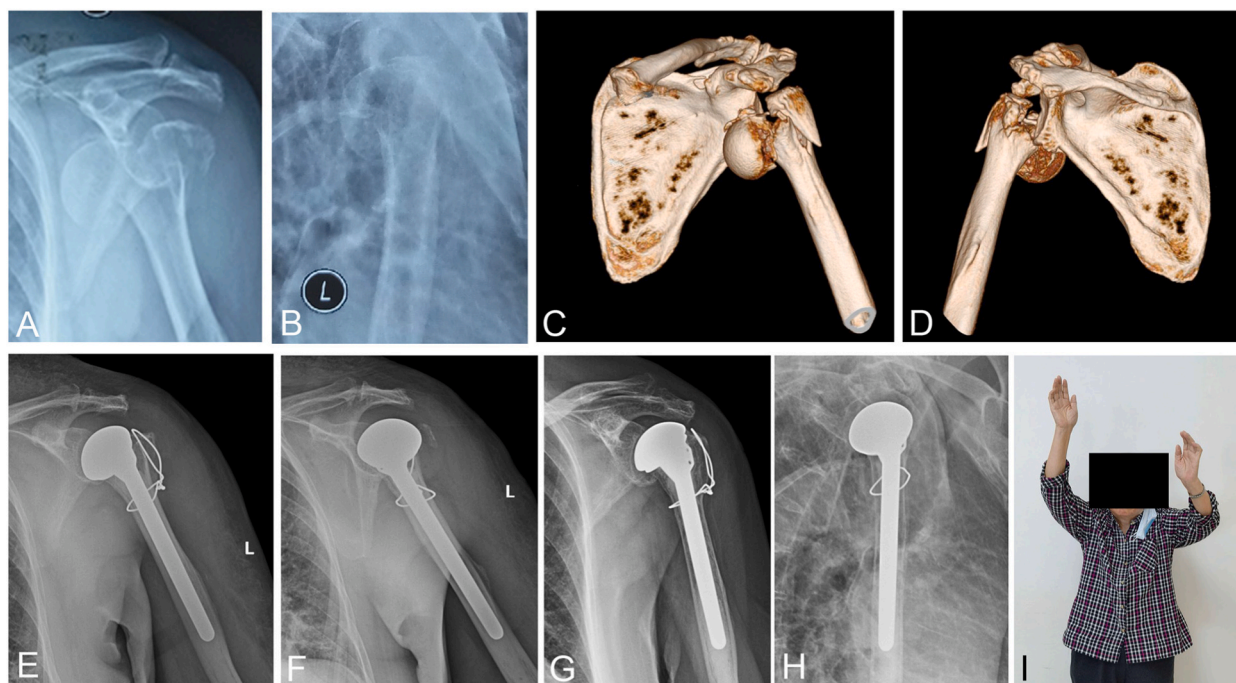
Locked fracture-dislocation of the proximal humerus in a 77-year-old female patient treated by shoulder hemiarthroplasty. Anteroposterior (a) and axial projection view (b) radiographs and three-dimensional computed tomography images (c, d) showing a three-part Neer fracture of the proximal humerus with the humeral head displaced anteriorly and locked onto the glenoid rim. Postoperative radiographs after hemiarthroplasty (e, f) showing the major tubercle fixed anatomically with wires. X-rays 50 months postoperatively (g, h) showing good joint congruence with no complications. (i) Photograph showing the clinical outcome 50 months after surgery.
